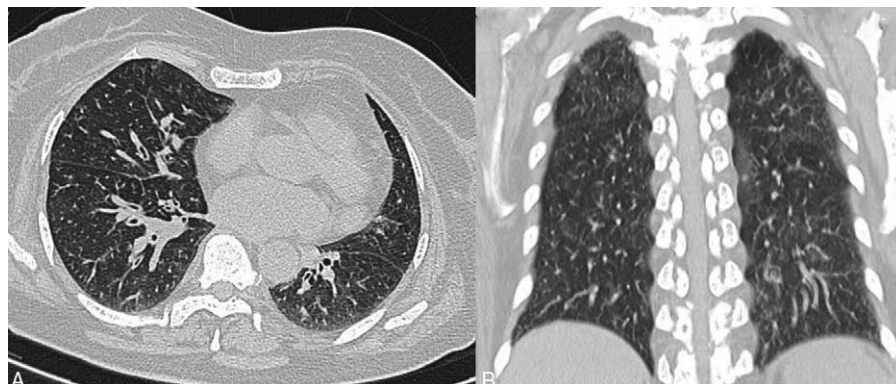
Unenhanced chest CT revealed multiple dots, nodules, and slightly high density lesions of diverse configuration, the boundary was not clear. No swelling lymph node, and pleural was thickened. Axial view (A) and coronal view (B).
